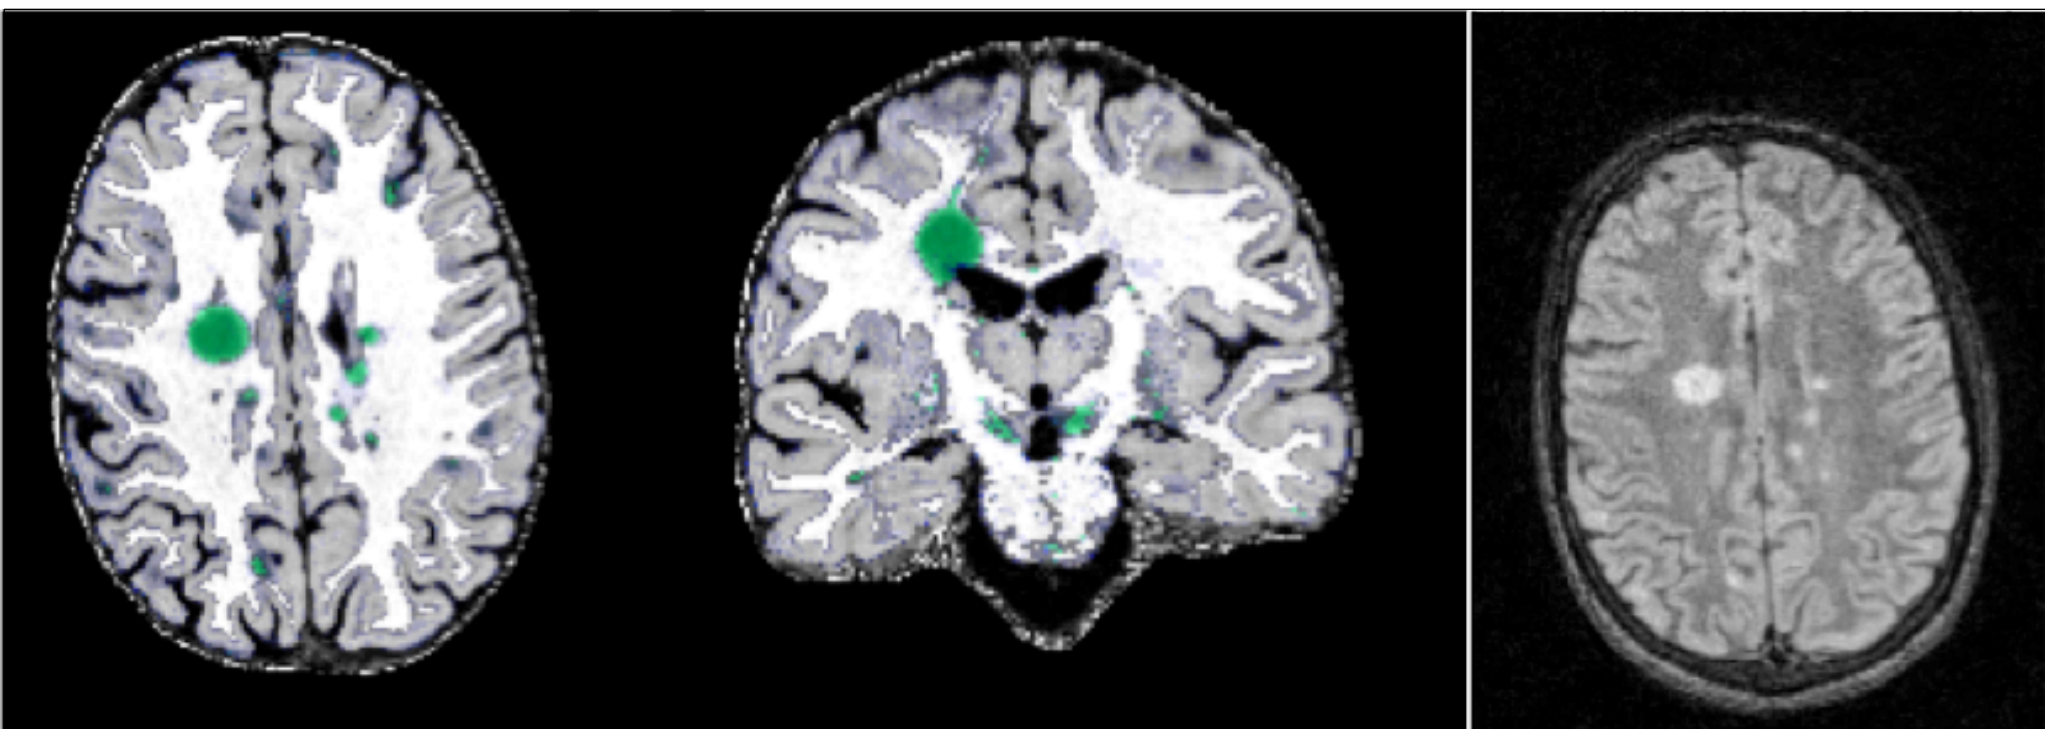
A posteriori probability maps obtained from 4 patients with different clinical courses and lesion loads compared to FLAIR 3D.
